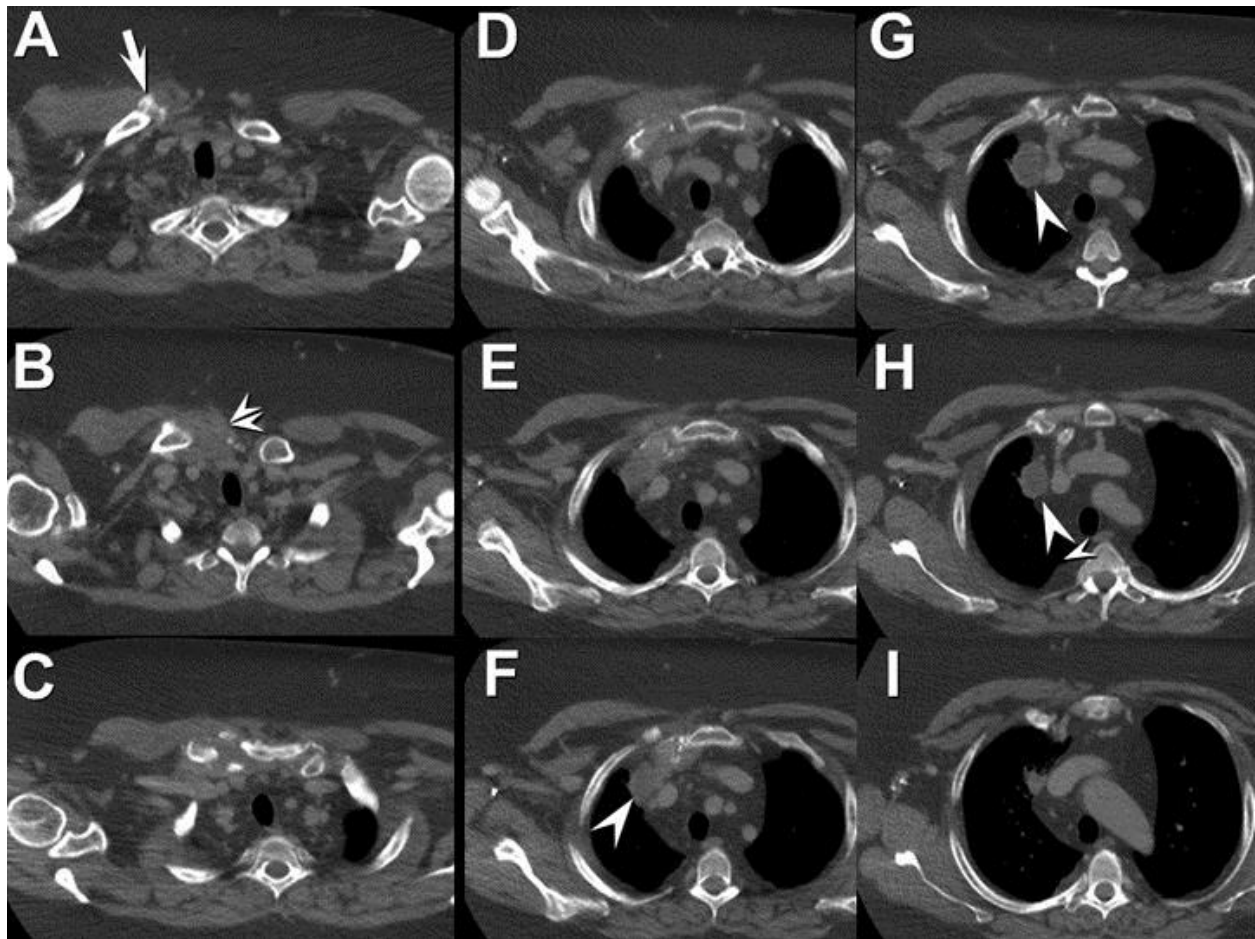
Axial unenhanced thoracic CT
